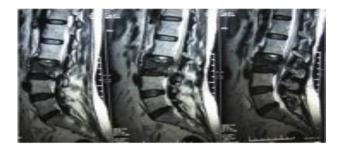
MRI picture of metastasis.
